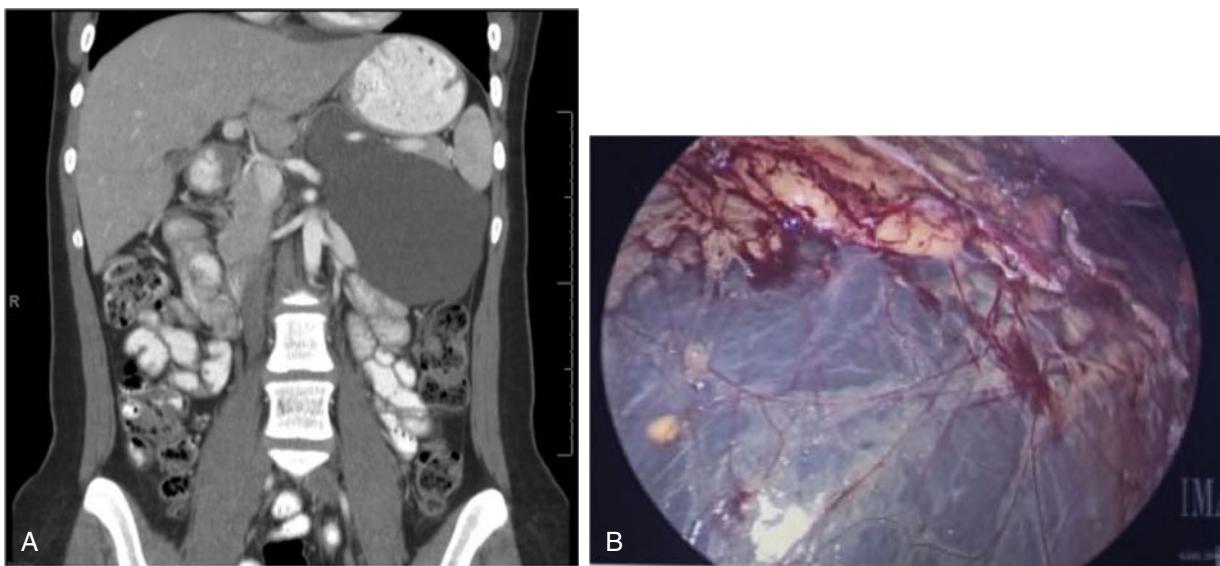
(A) CT scan of a 15-year-old girl who had left upper quadrant pain and was noted to have a $10.7 \times 11.3 \times 8.4$ cm cyst in the left side of the abdomen. The cyst was medial to the spleen, posterior to the pancreas and splenic artery and vein, and anterior to the left kidney. (B) Intraoperative view of the cyst on laparoscopy. Final pathology was consistent with a lymphatic malformation.
